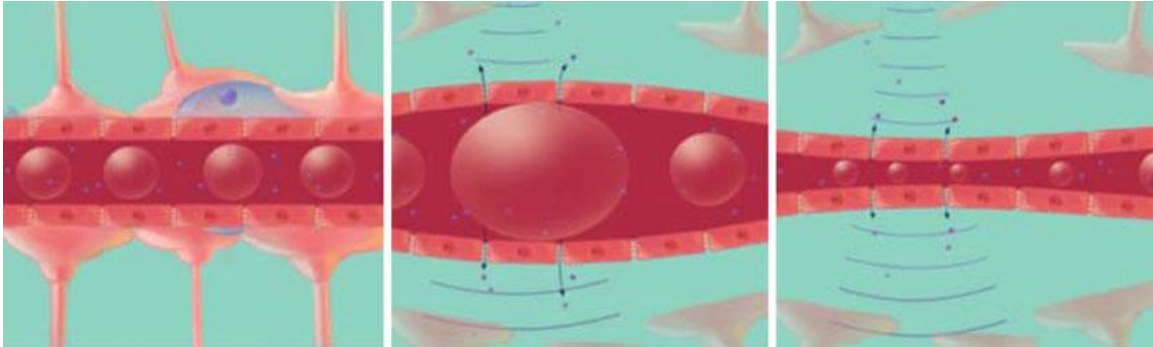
As microbubbles pass through comparable sized vasculature, ultrasound insonification causes them to expand and contract, separating cells and opening the tight junctions between them. Used with permission from [55]. See Appendix A for Copyright.
